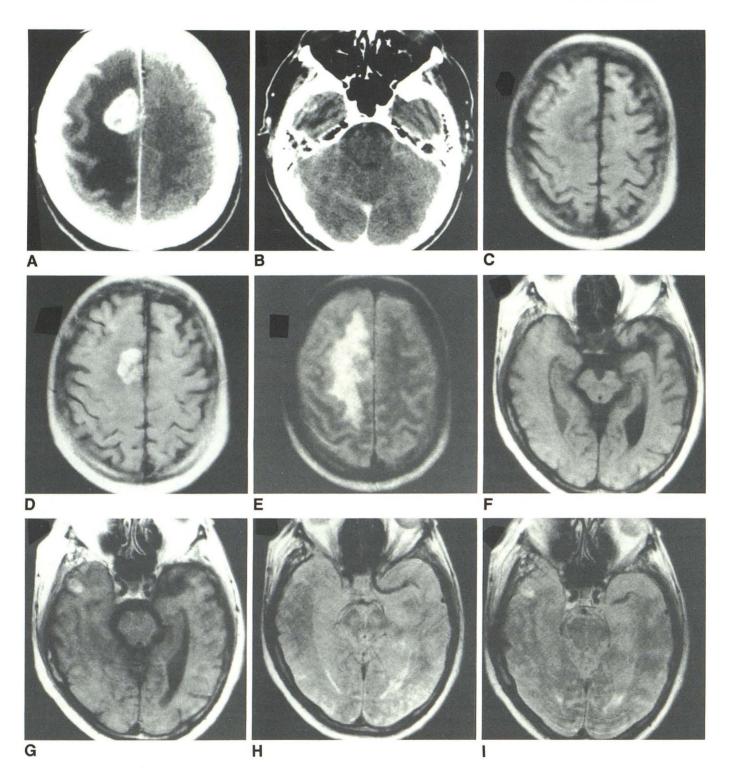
62-year-old man with left arm weakness and dysarthria progressing over 3 weeks. A, CT shows enhancing lesion in right hemispheric white matter, surrounded by low density. B, CT section of temporal lobes degraded by streak artifact. C, TR = 500, TE = 30 msec. D, TR = 500, TE = 30 msec after Gd-DTPA. Lesion enhances. E, TR = 2000, TE = 60 msec. Localization of lesion and differentiation from surrounding edema are possible on pre-Gd-DTPA sequences (C, E). Primary tumor was suspected. F, TR = 500, TE = 30 msec.
